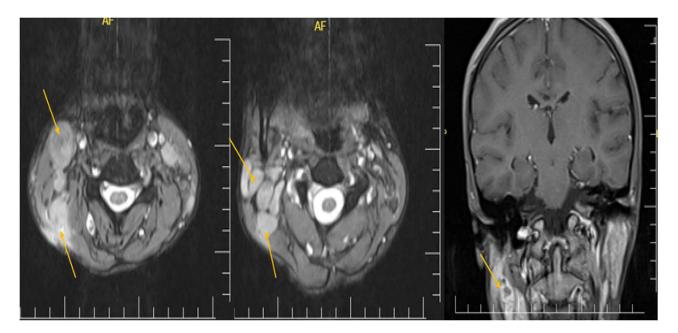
Cervical axial T2-weighted images and coronal T1-weighted post-gadolinium scans revealed multiple conglomerate cervical lymphadenopathies (Arrows).
